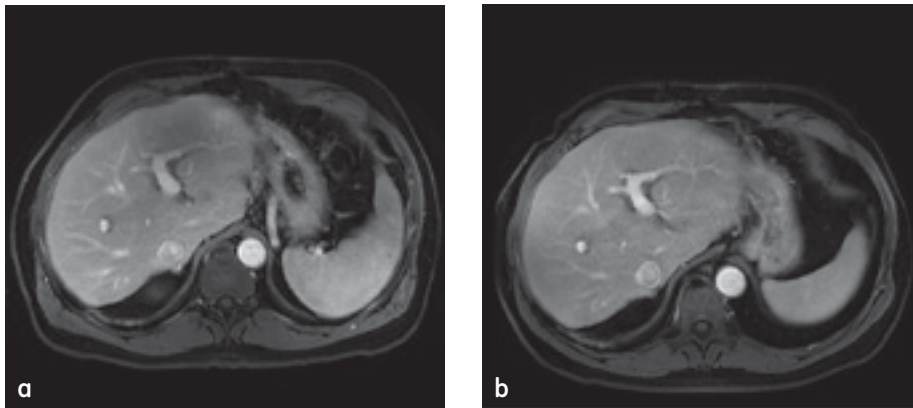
(a) MR image from December 2008, initial post-liver transplantation MR. (b) March 2009, liver biopsy shows mild fibrosis.
